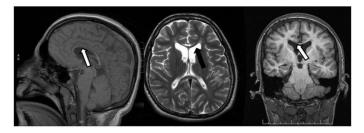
MR Brain Scan Showing a Thin Corpus Callosum. Sagittal brain magnetic resonance imaging of the patients with an SPG11 mutation demonstrating a thin corpus callosum (arrowed), a useful clue to this diagnosis (left, sagittal T1; center, axial T2, right, coronal T1 gradient echo).
